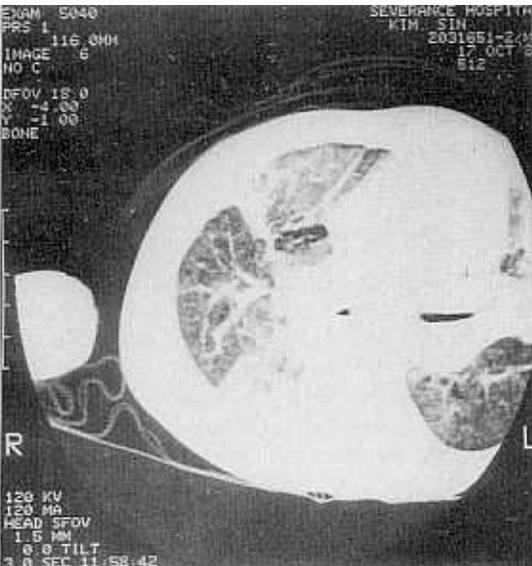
Chest CT shows multiple, linear or nodular opacities of both lungs.
